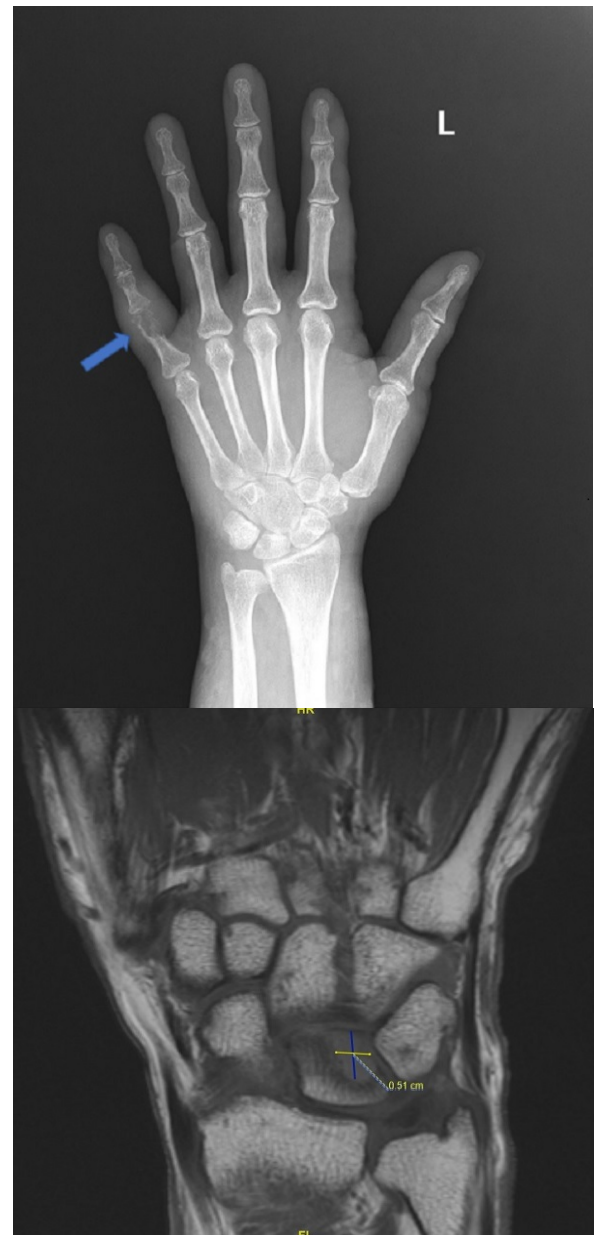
Radiologic imaging of the left upper extremity. A: Left hand X-ray with a lytic lesion of the 5th phalanx presumed to be another site of bony involvement. B: Left wrist MRI showing disseminated MAC involving the lunate bone.
